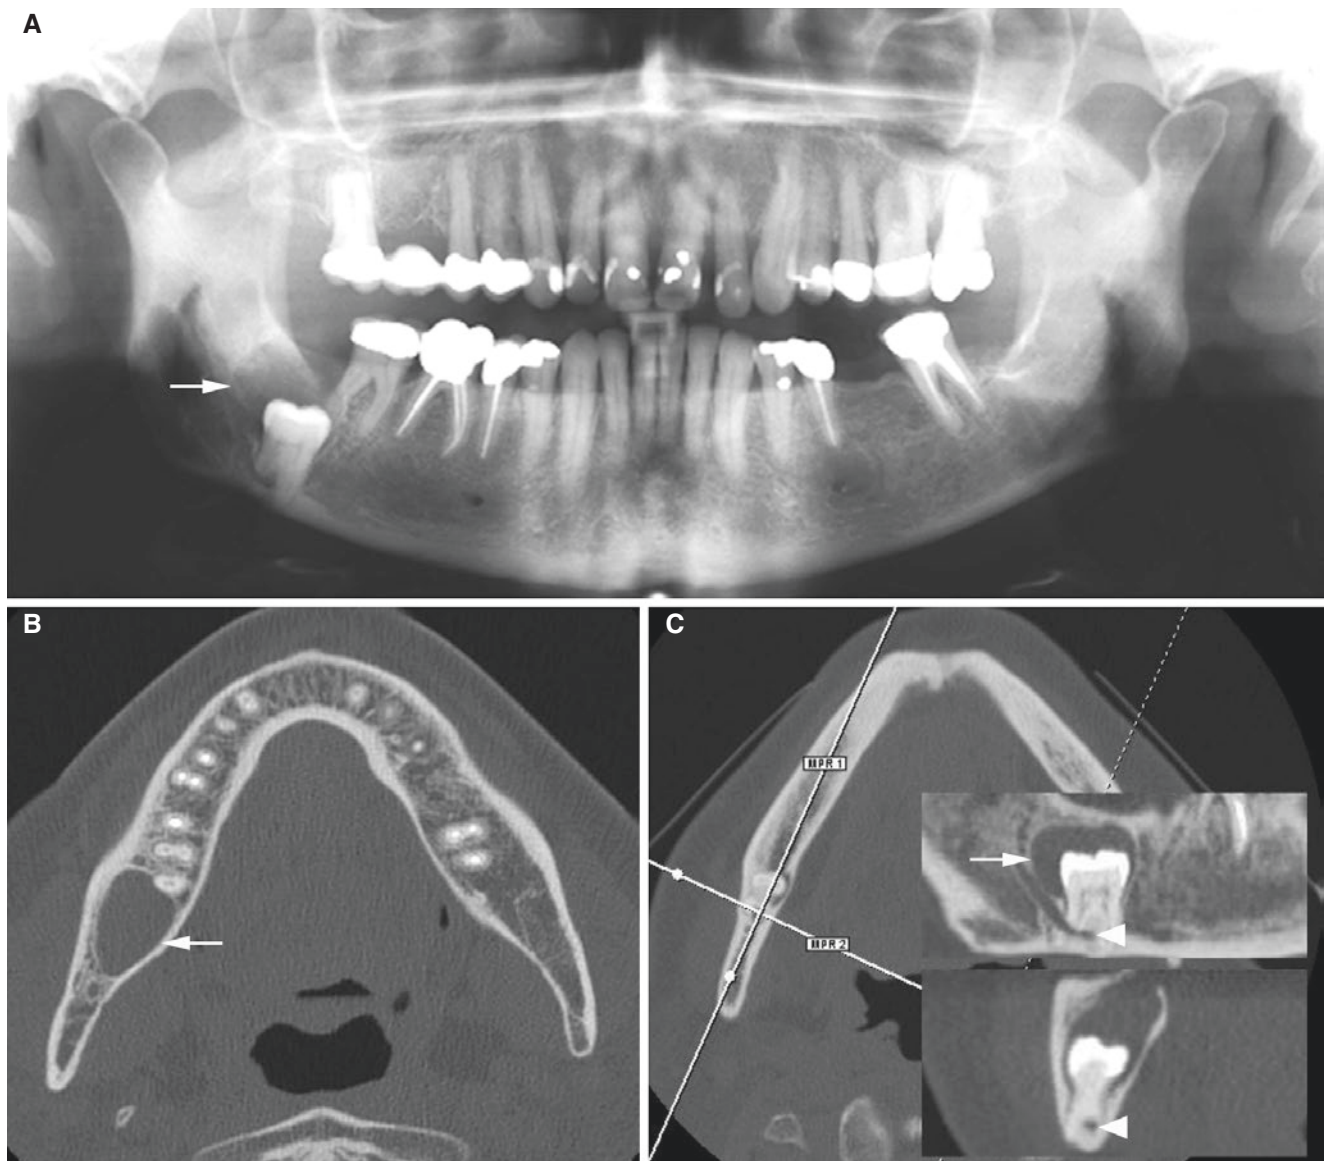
Impacted wisdom tooth, follicular cyst, mandible; 58-year-old patient with incidental finding. (A) Panoramic view shows wisdom tooth in right mandible with pericoronal radiolucency (*arrow*). (B) Axial CT image shows radiolucency with no or minimal buccal or lingual expansion (*arrow*) and no root resorption. (C) Axial (with *cursor*
